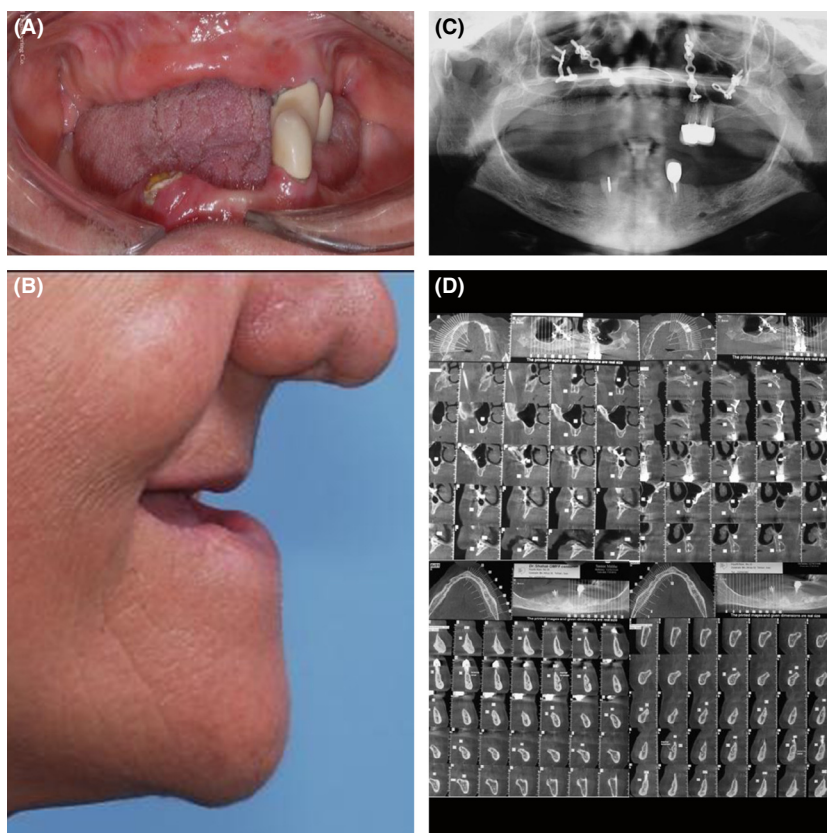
(A) Preoperative intra-oral frontal view. (B) Preoperative lateral view of the patient. (C) Preoperative panoramic view. (D) Preoperative CT scan views.
